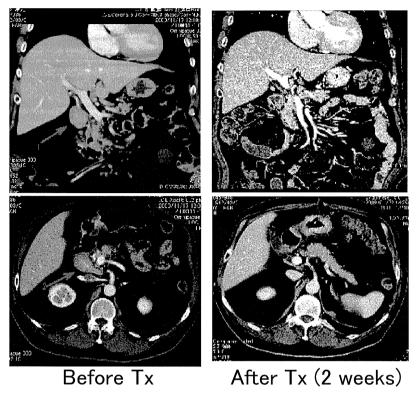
Abdominal enhanced CT in patient with IgG4-related lymphadenopathy. Abdominal lymph node swelling completely disappeared after treatment with glucocorticoids for two weeks.
